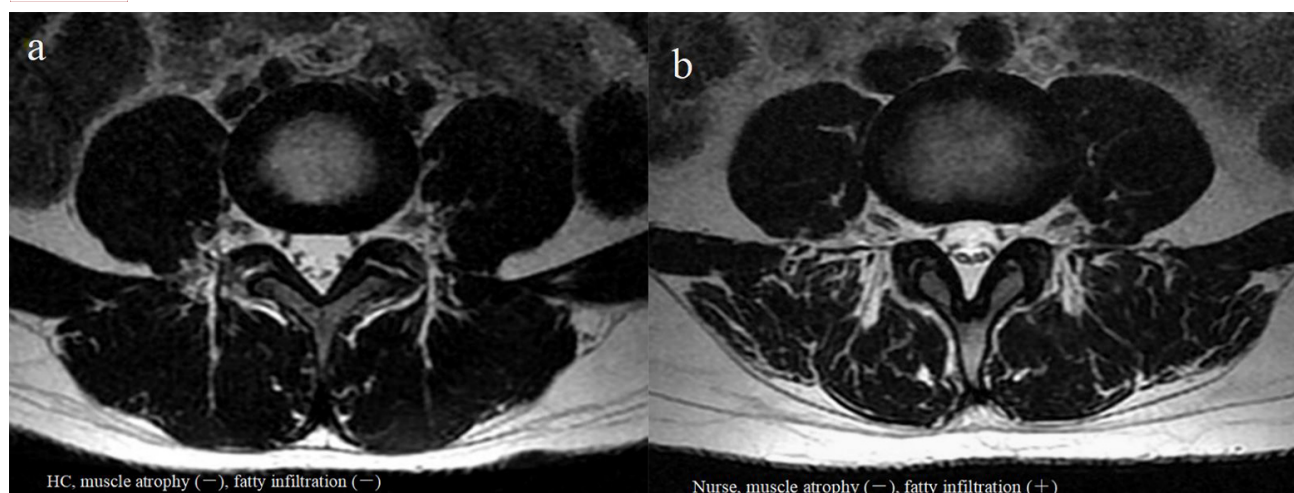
Comparison of axial T2-weighted MR images of lumbar paraspinal muscles between healthy controls and CBNLBP. (a) Lumbar paraspinal muscle of healthy control. (b) The MRI signal intensity of the extensor muscle was significantly higher than that of the flexor in nurses. Note: “-” indicates no muscle atrophy or fatty infiltration, “+” indicates muscular atrophy or fatty infiltration.
